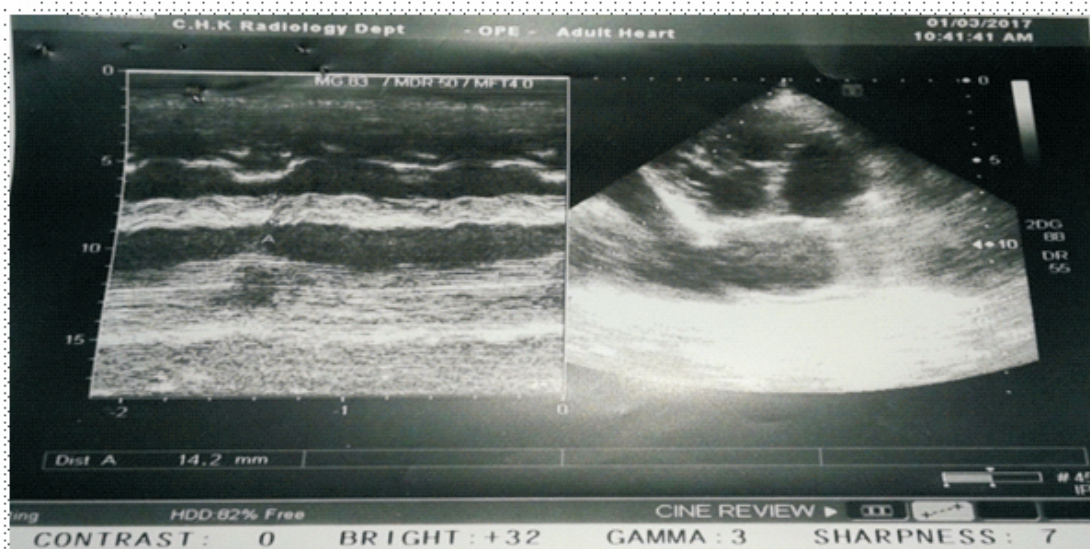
3 2D Echocardiogram (Parasternal long axis view) showing stenotic pulmonary valve.
